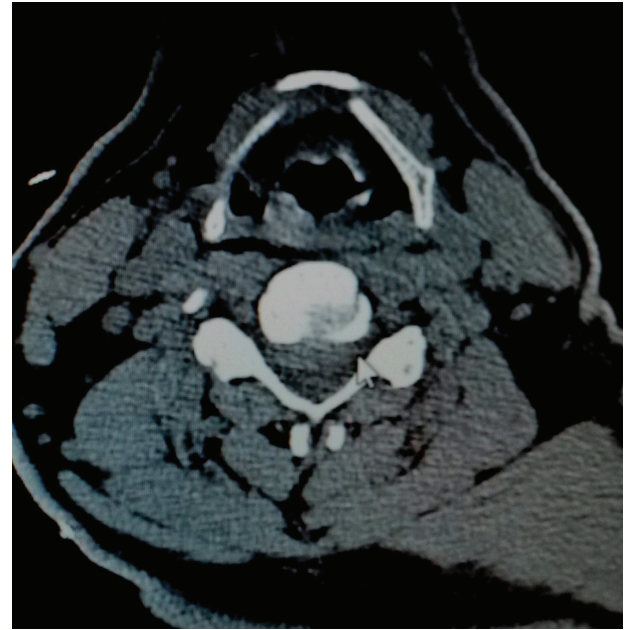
Postoperative axial computed tomography shows the epidural hemorrhage and cord
